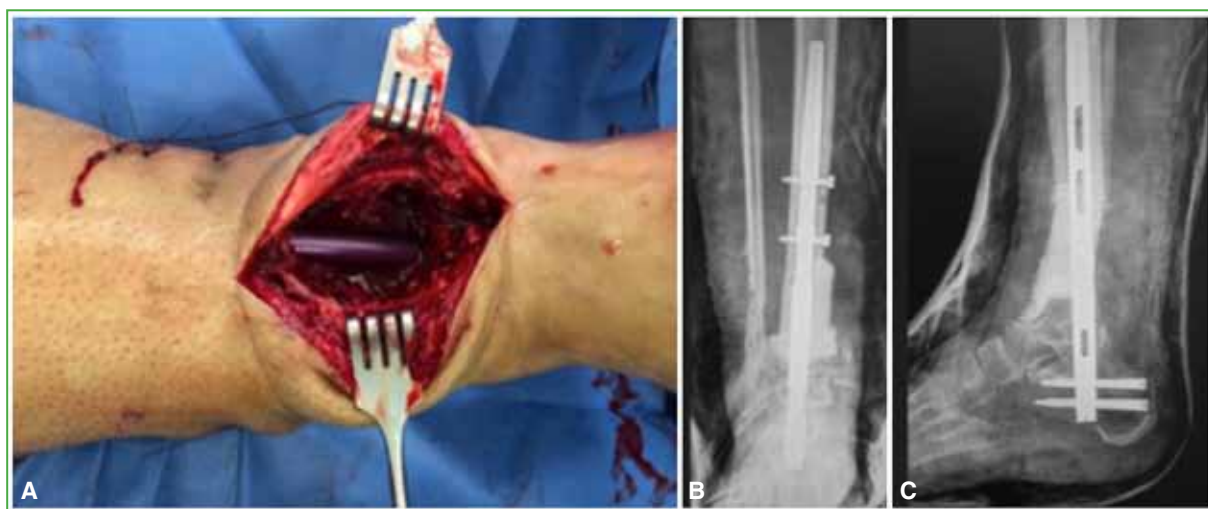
A. Intraoperative image of bone resection and stabilization with intramedullary nail. B and C. Anteroposterior and lateral ankle radiographs after the first surgical stage.
